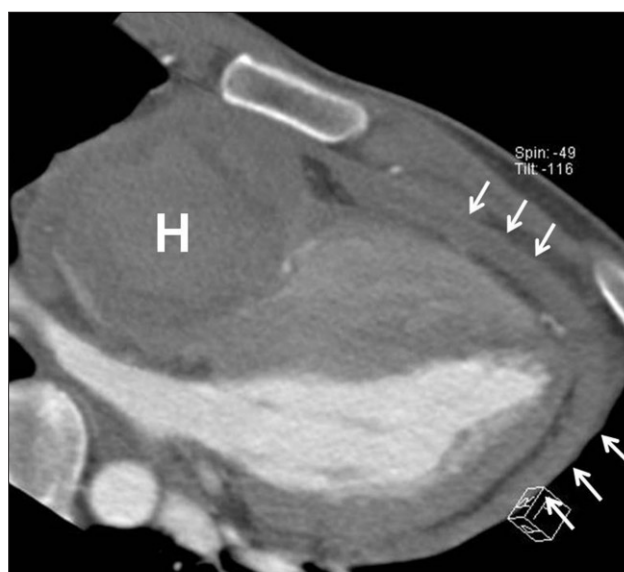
Four-chamber view of multidetector computed tomography on admission. It revealed a 60×60 mm-sized, round mass (H, hematoma) compressing the right atrium and the tricuspid annulus and small amount of hemopericardium (arrows).
